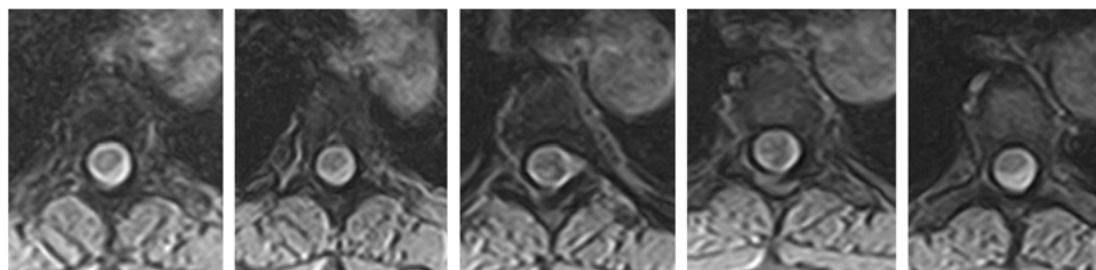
Axial T2 MRI - emphasize intradural lesion, in postero-lateral left position, with discreet compression over the spinal cord, displaced anteriorly and laterally and to the right
